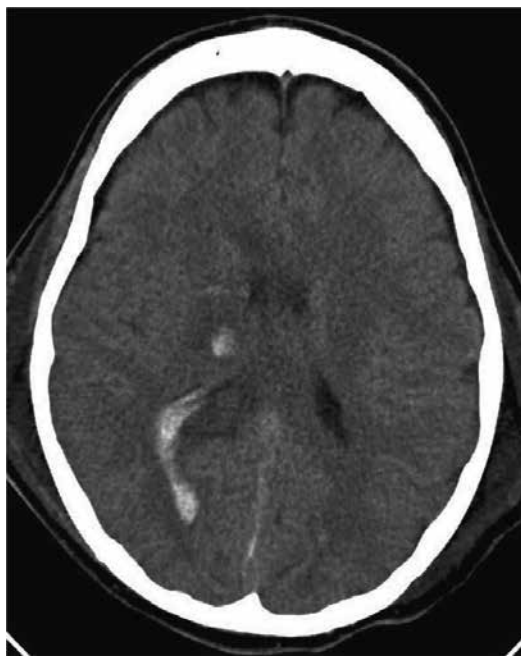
CT scan of a 25-year-old male patient who sustained a motor vehicle accident. He presented with hypothermia and refractory hypoxemia from severe pulmonary contusions. Despite intraventricular hemorrhage, he was supported on veno-veno ECMO for 4 days, 2 days without the use of systemic heparin. He was successfully weaned from ECMO, extubated, and discharged to a rehabilitation facility 21 days postinjury (see text for reference).
